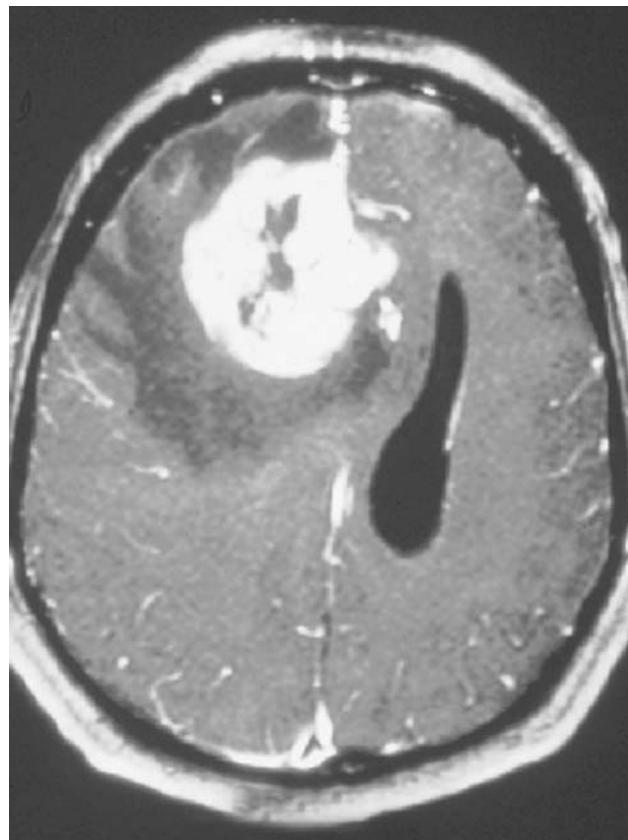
This MRI scan shows the typical appearance of a glioblastoma within the CNS as visualized with contrast. Note how the gadolinium contrast agent has leaked out of the disrupted blood-brain barrier and demarcated the position of this "ring-enhancing" lesion. This tumor has a necrotic core that appears hypodense. Note the edema (*dark border*), which surrounds the tumor. The ipsilateral lateral ventricle has been obliterated by the increased intracranial pressure generated by this space-occupying mass.
